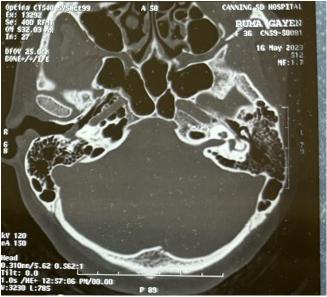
Axial CT scan of temporal bones showing a focal soft tissue density area in between the tympanic membrane and the promontory on the right side.
